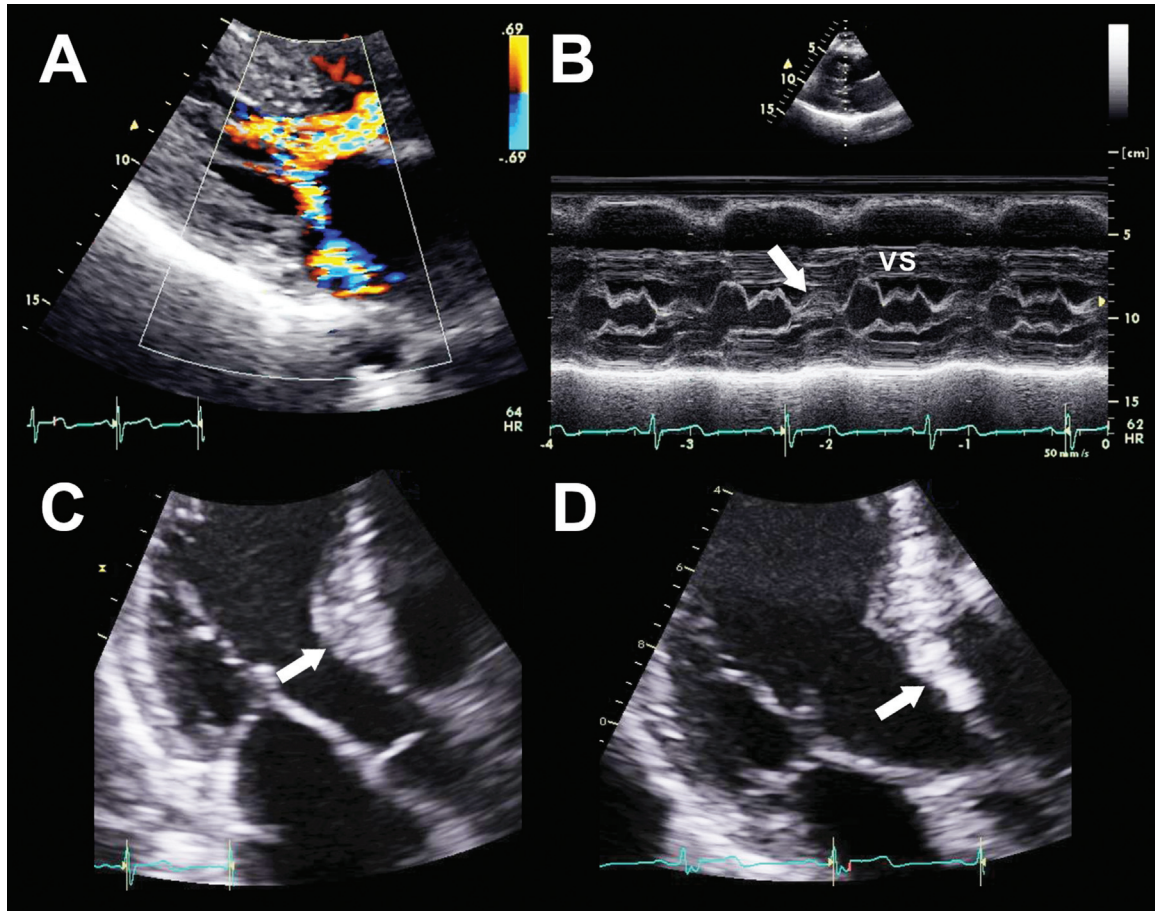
(A) Systolic anterior motion with posteriorly directed mitral regurgitation, thickened left ventricular septum, and turbulent left ventricular outflow tract outflow. (B) M mode shows systolic anterior motion of the mitral valve (arrow) and a thickened septum. Echocardiography shows a thickened septum (arrow, 2 cm) before alcohol septal ablation (C). On follow-up, echocardiography demonstrates a reduction of septal thickness to 1 cm at the site of alcohol septal ablation (D, arrow); tissue characteristics are echodense, indicating fibrosis. VS, ventricular septum.
